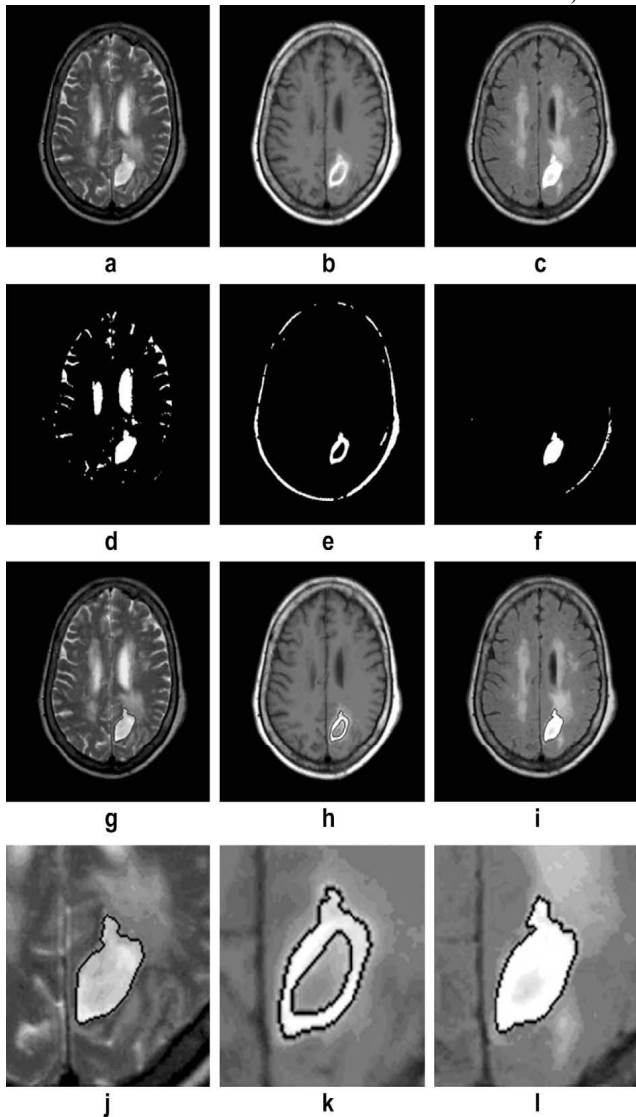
(a–c) are for original MRI images, (d–f) are after binary images, (g–i) are after Otsu clustering images, and (j–l) are for localized images.
